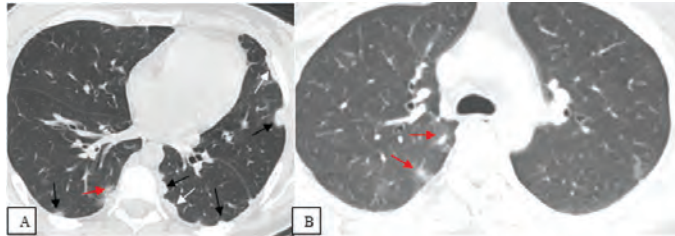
Axial CT images showing. A) Bilateral nodular pulmonary infiltration predominantly peripheral in distribution (A, black arrows) in a 30-year-old immunocompromised female patient presenting with cough, fatigue, and nausea who had a history of esophageal cancer and was discharged from the hospital 8 days after being hospitalized for COVID-19 pneumonia. Note also the subpleural GGOs (A, red arrow) and consolidations (A, white arrows). B) GGOs surrounding the nodular consolidations in the right lower lobe resulting in halo sign (B, red arrow) in a 51-year-old immunocompromised female patient presenting with fever and dyspnea, who had a history of diffuse large B-cell non-Hodgkin lymphoma was discharged from the hospital 10 days after being hospitalized for COVID-19 pneumonia
